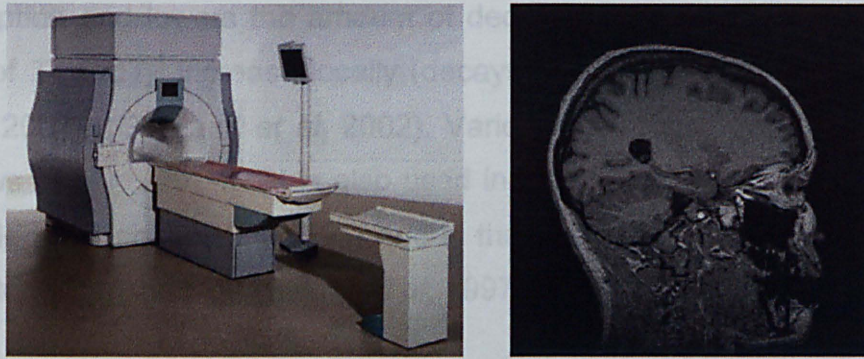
LEFT: A conventional MRI scanner, RIGHT: Sagittal view, showing excellent soft-tissue contrast between grey and white matter and high spatial resolution. Extracted from (Suetens, 2001) (p80).
